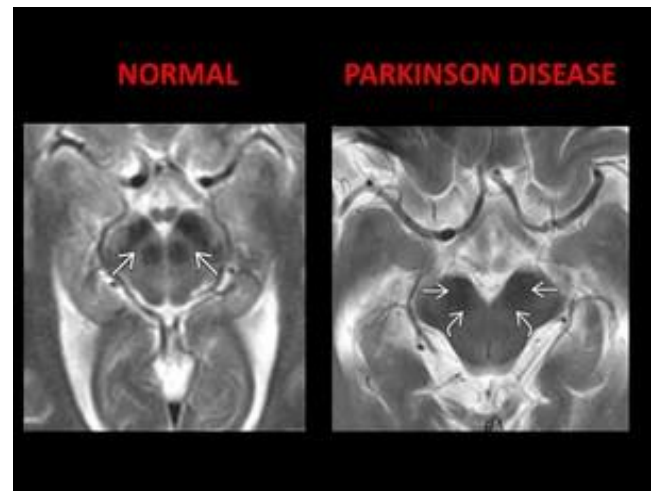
Axial T2 MR images compare normal midbrain with Parkinson disease midbrain. Second image shows blurring and thinning of pars compacta. Subsequently, the red nuclei and substantia nigra are almost touching.
